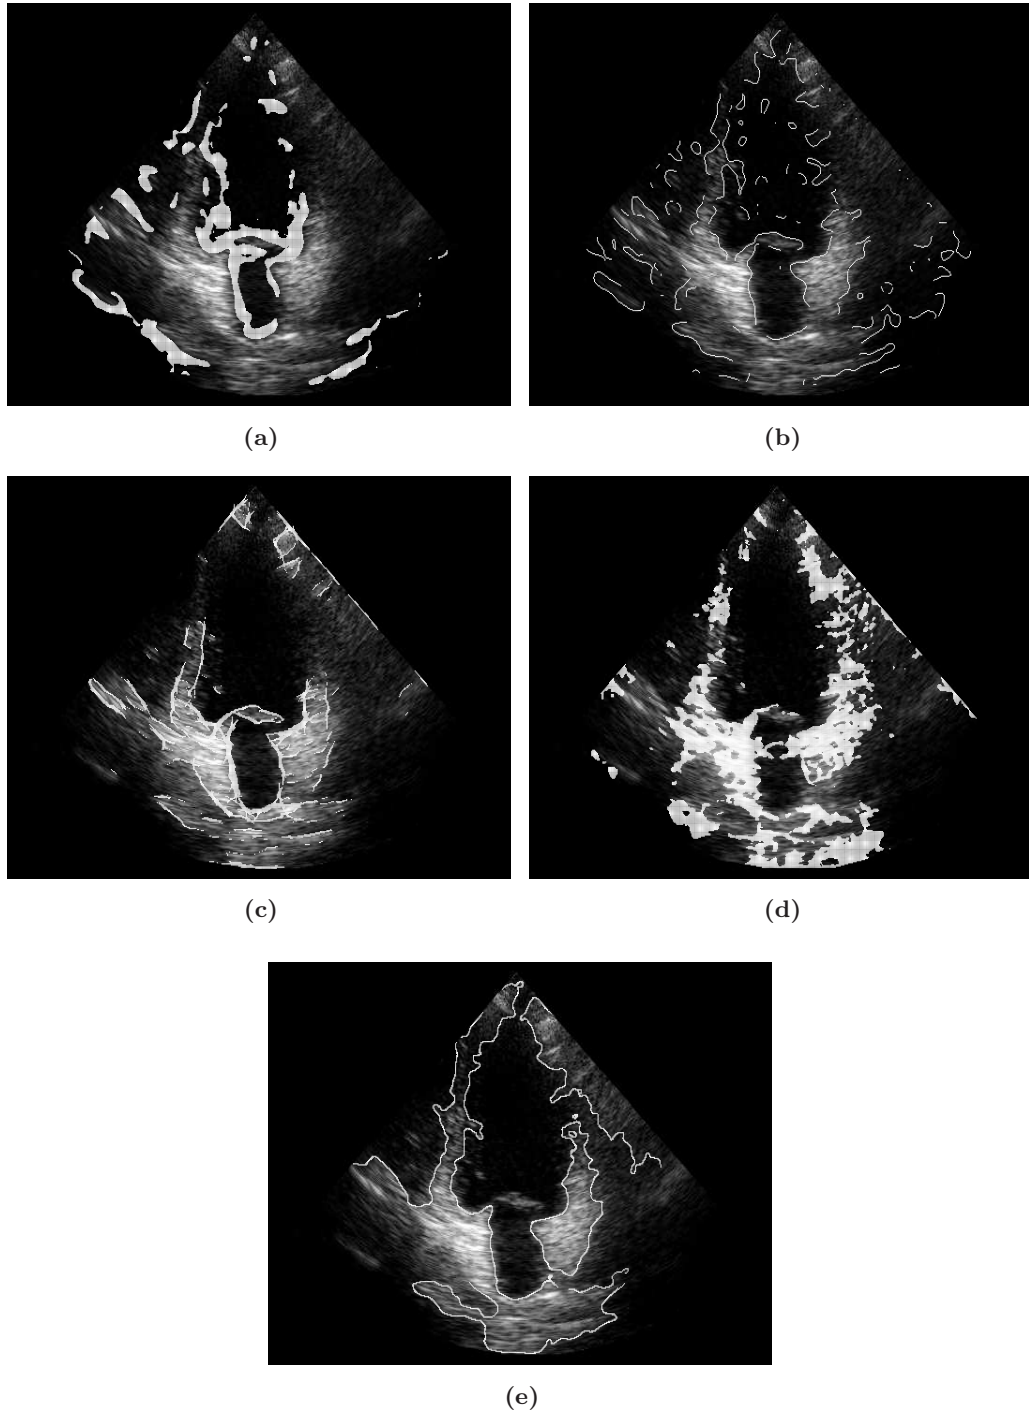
Edge detector output for the clinical ultrasound images of Fig. 6.8(a). (a) CV, (b) RoA, (c) FA, (d) PC, (e) ZC.
